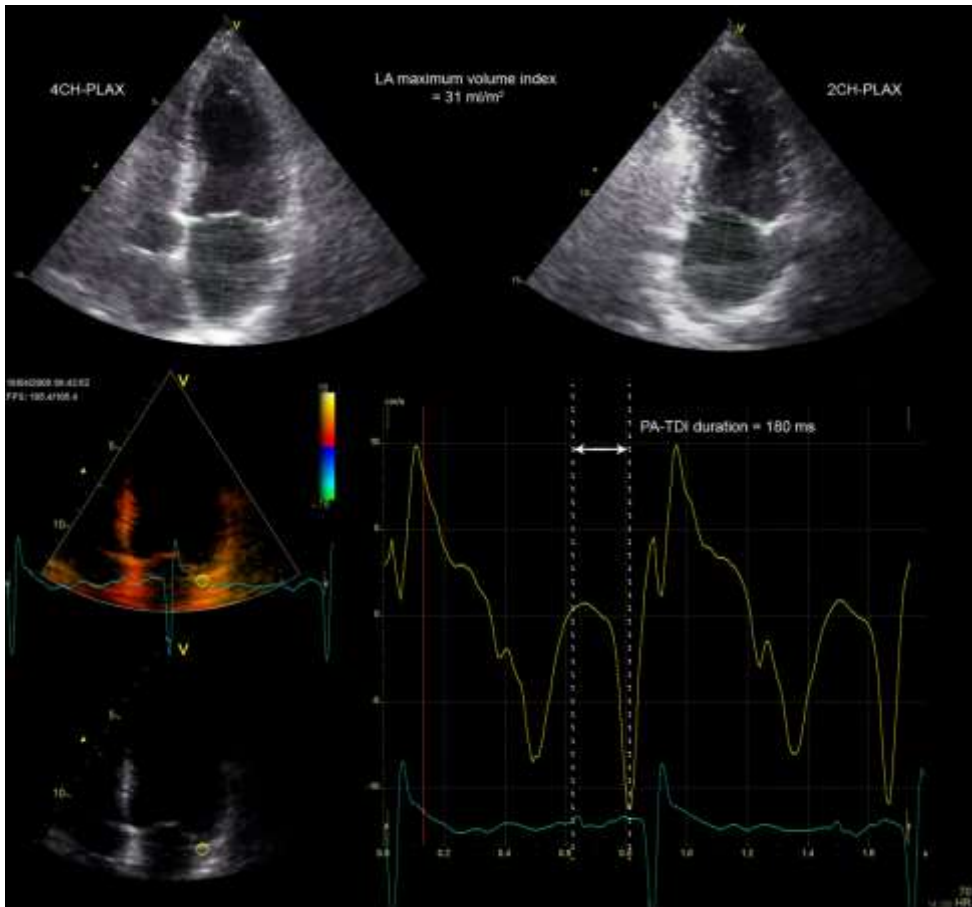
Example of a patient with a small left atrial (LA) size and a long total atrial conduction time (PA-TDI duration). The LA maximum volume index was obtained from the 2- and 4-chamber parasternal long-axis views (2CH-PLAX and 4CH-PLAX, respectively) and measured 31 ml/m². A tissue Doppler tracing of the LA lateral wall demonstrated a PA-TDI duration (arrow) of 180 ms. Despite the small LA size, the long PA-TDI duration indicates a large extent of atrial remodeling. This patient has experienced recurrence of atrial fibrillation during follow-up.
